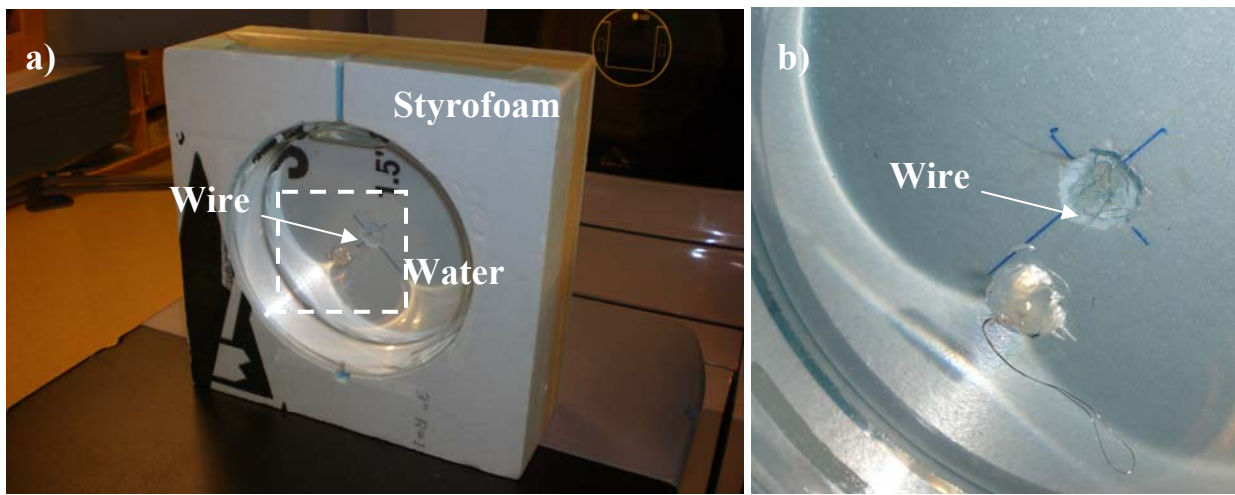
a) A steel wire under tension suspended in a 20.5 cm diameter water bath was used to measure the line spread function (LSF) of our CBCT system. The diameter of the wire was 0.157 mm. b) The magnified view of the selected region in a).
